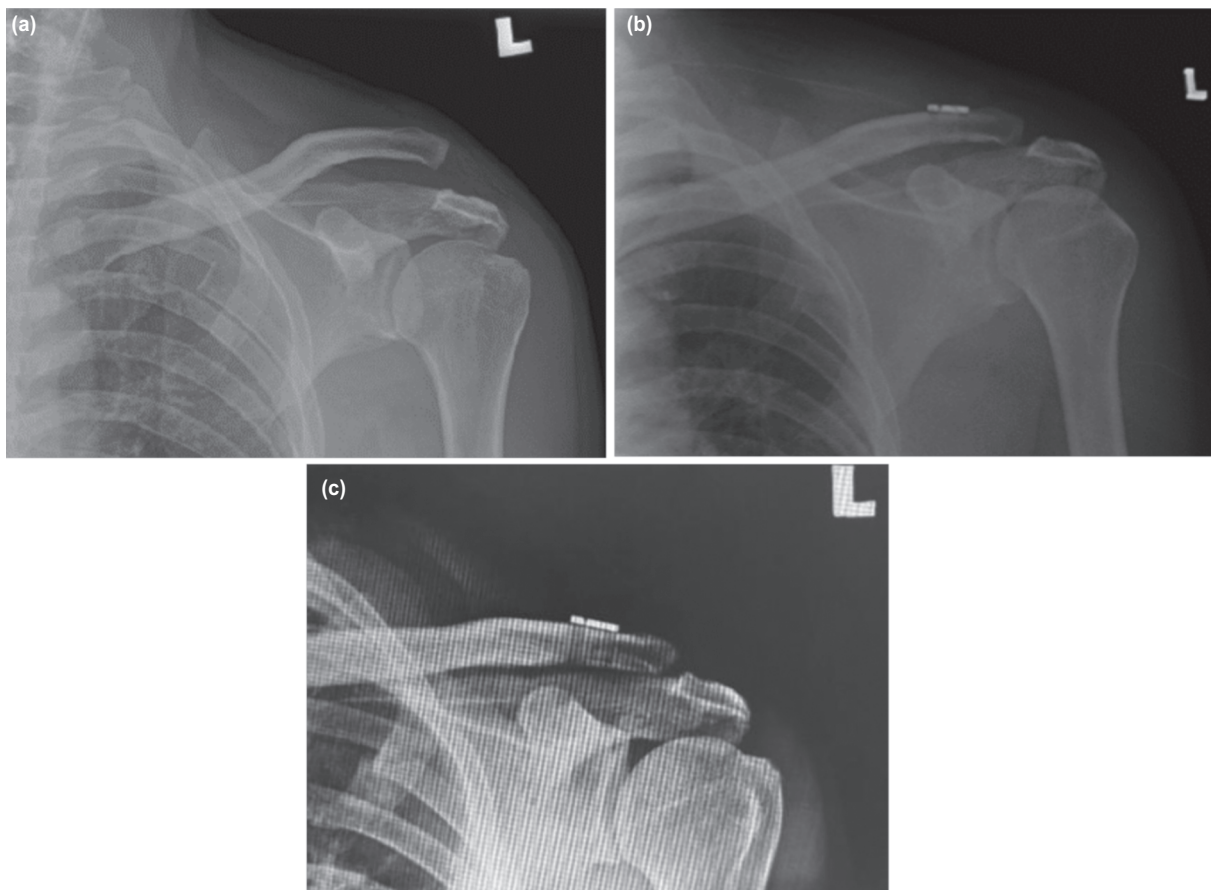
(a) Preoperative anteroposterior radiograph of left shoulder showing Rockwood's grade V AC joint dislocation. (b) Immediate postoperative radiograph showing left AC joint reduced. (c) At 6 week follow-up, left AC joint reduction was maintained, no graft or hardware failure noted.
